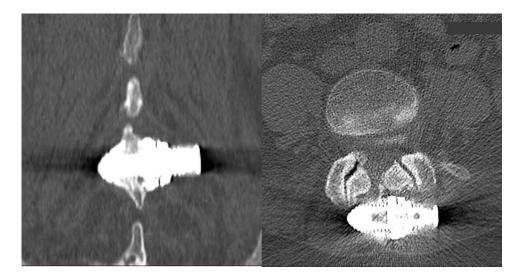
Representative CT scans of a fused segment.
